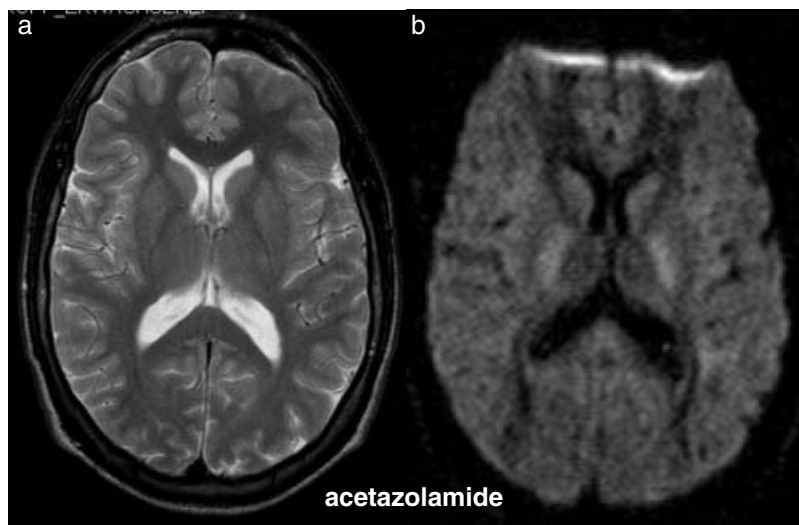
T2 weighted (a) and diffusion weighted (b) magnetic resonance imaging in the same subject (no. 3, with acetazolamide, see Table 1) with only mild symptoms of AMS without abnormal increase in signal intensity.
